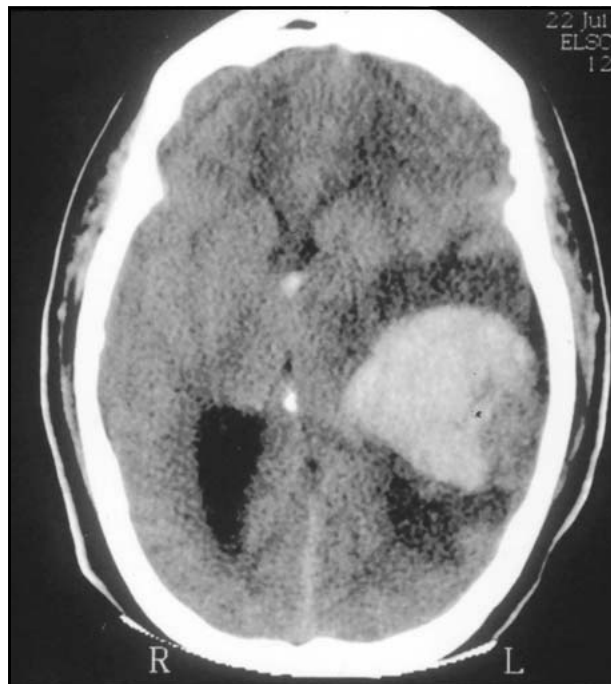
CT scan after neurological deterioration shows an increase in blood volume. Edema and mass effect can be seen.
